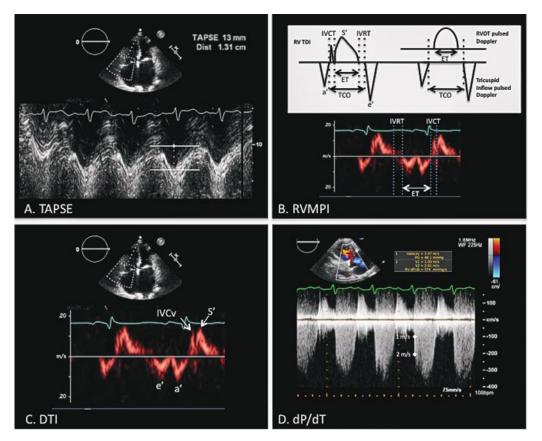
Surrogate echocardiographic markers of right ventricle (RV) function. A, Tricuspid annulus plane systolic excursion (TAPSE). M-mode cursor placed through the RV apex to the lateral tricuspid annulus in the apical 4-chamber view for the purpose of measuring the distance traveled by the annulus in centimeters from end-diastole to end-systole. Abnormal TAPSE of 1.3 cm is noted by cross-hatching. B, RVMPI (Tei index). Top, representation of the two ways to calculate RVMPI: on tissue Doppler and on pulsedwave Doppler. Bottom, isovolumic contraction and relaxation times (IVCT and IVRT, respectively) and ejection time (ET), where right ventricular myocardial performance index (RVMPI) = (IVCT + IVRT)/ET. C, Doppler tissue imaging (DTI) of the tricuspid annulus after pulsed-wave interrogation of the lateral wall of the tricuspid annulus. These measurements can be made after high-frame-rate acquisition with color-coded Doppler offline (not shown). IVCv: isovolumic contraction velocity; S': highest systolic velocity. D: Rate of pressure rise in the RV, or the dP/dT. On the ascending limb of the continuous Doppler image of the tricuspid regurgitation jet, the time for the velocity to increase from 1 to 2 m/s is measured, and the dP/dT is 12 mmHg/time in seconds.
